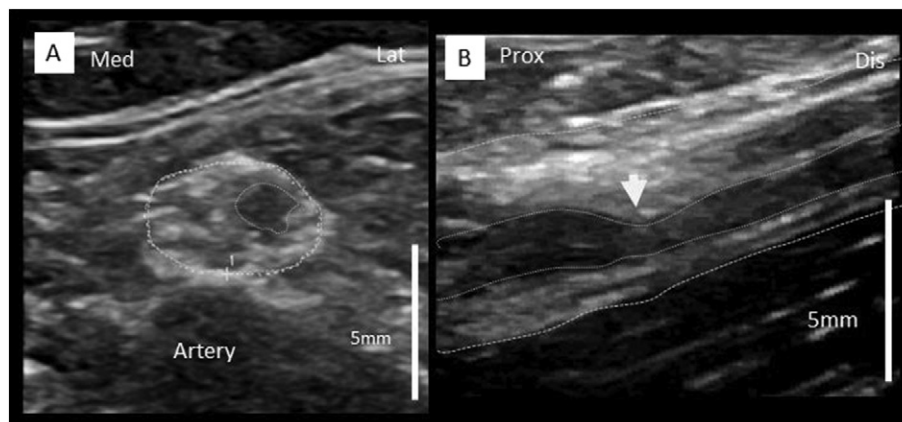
Ultrasonograms of patient 2. A: Cross-sectional scans of the median nerve in the region 3 cm proximal to the elbow (cross-sectional area: 20 mm²). B: A longitudinal scan showing constriction of a fascicle of the median nerve at the elbow. Nerves with hourglass-like, incomplete constrictions and enlargements are shown. Dashed line: nerve epineurium, dotted line: nerve fascicle, arrowhead: hourglass-like constrictions, lat: lateral, med: median, dis: distal, prox: proximal.
